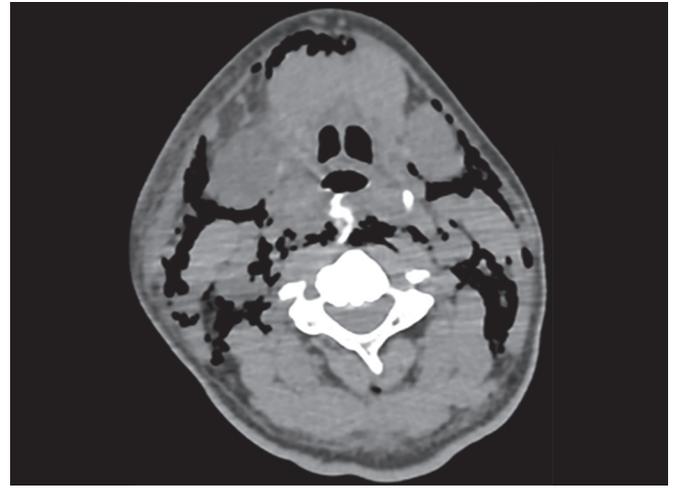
Computed tomography neck axial section showing the contrast extravasation through the perforated esophagus
